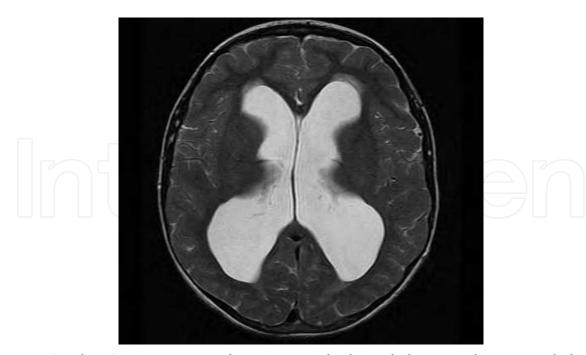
a. Axial T2W MRI sequence demonstrating hydrocephalus secondary to tectal glioma. The child underwent endoscopic 3rd ventriculostomy with good outcome.
